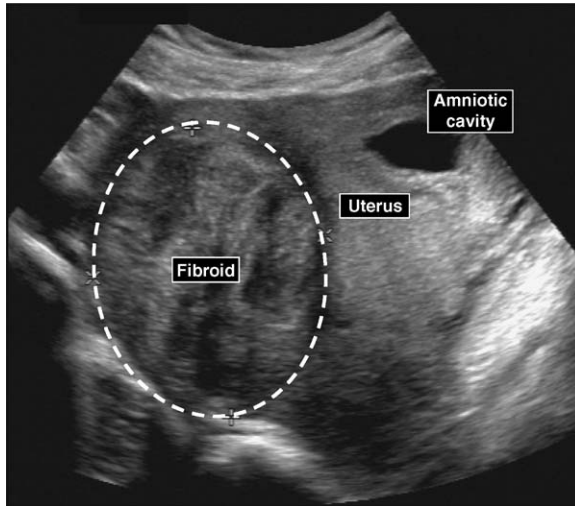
Degenerating fibroid. A large (7.1×5.8 cm) intramural and subserosal fibroid is shown in the fundal region of a uterus that contains a viable 12-week intrauterine pregnancy. The patient presented with lower abdominal pain, low-grade fever, nausea, and localized tenderness over the uterine fundus, which suggested a diagnosis of a degenerating fibroid. The presence of a large fundal fibroid on ultrasound with echogenic irregularities that are suggestive of necrosis likely confirms the diagnosis.
